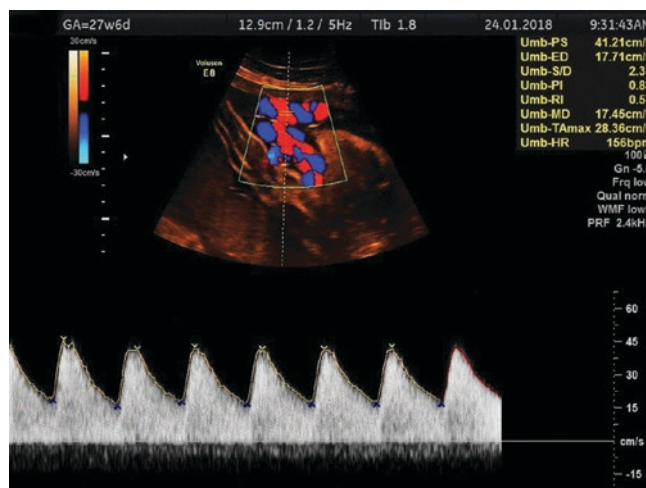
Normal umbilical artery Doppler waveform
